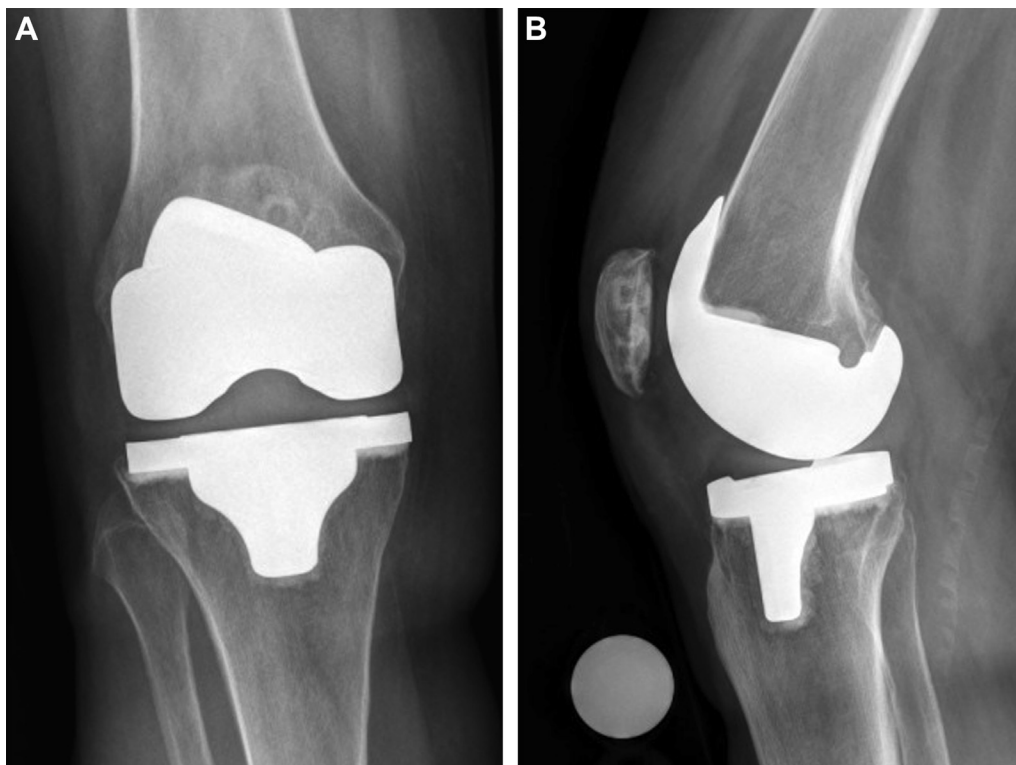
(A) Anteroposterior and (B) lateral radiographs of the posterior-stabilized total knee arthroplasty (Triathlon; Stryker, Mahwah, NJ).
